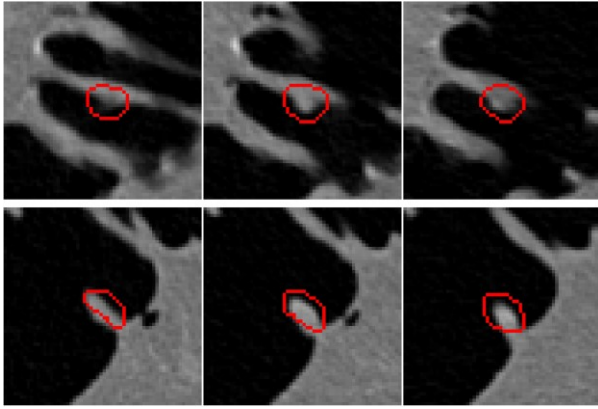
Figures of a polyp example. The two rows represent the same polyp from two corresponding CT scans. Each row has three slices of the same polyp outlined by red lines. The lower one itself is very hard to detect if the other CT scan is neglected.
